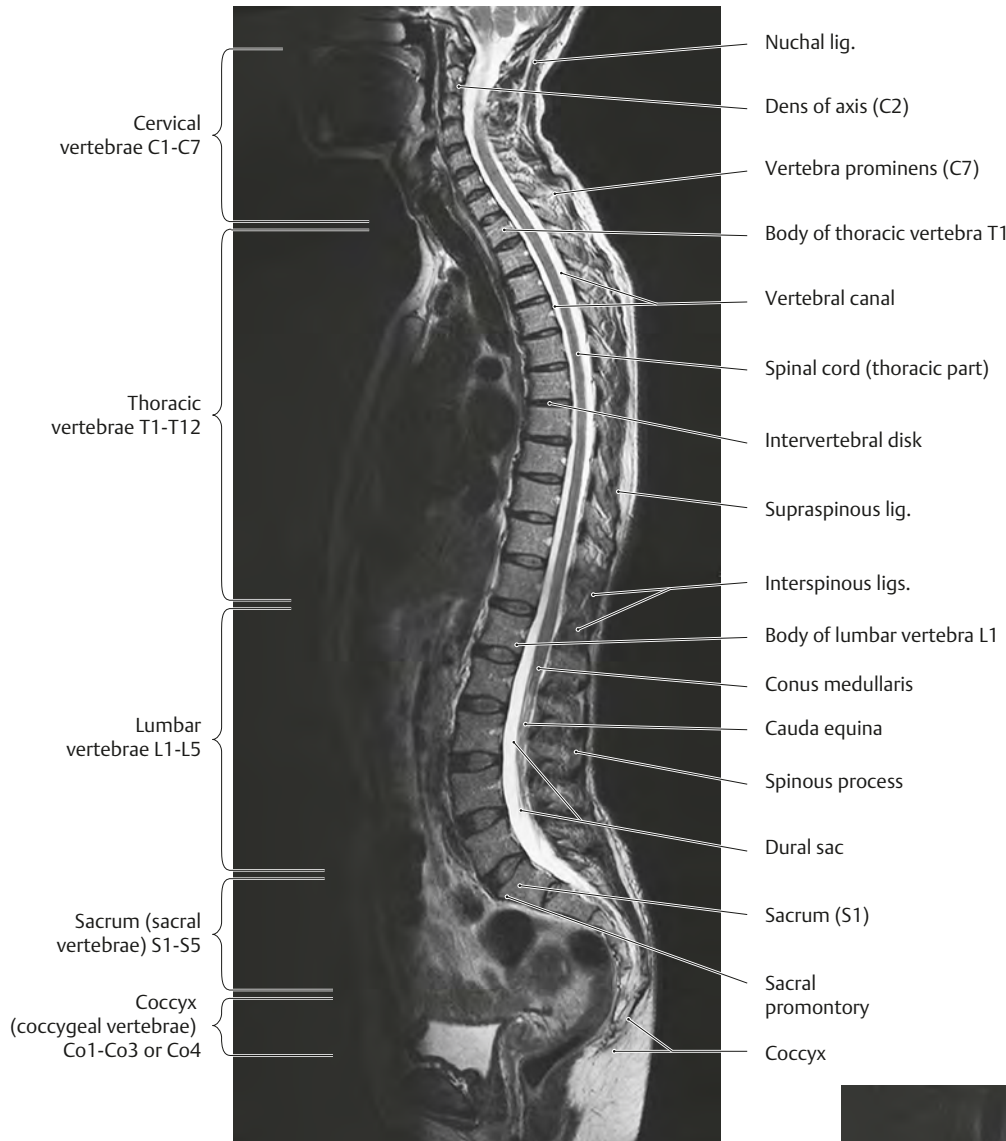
MRI of the spine
